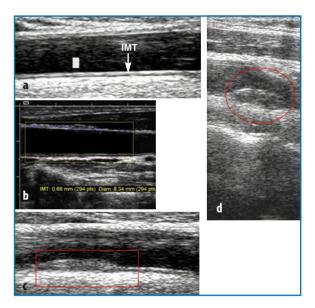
Progressive stages of atherosclerotic plaque build-up in the carotid artery in HIV-infected patients. a An increase of the arterial intima-media thickness (*IMT*) is the first step of this evolution. It occurs before plaque build-up in the arterial wall. b IMT can be measured ultrasonographically using specific analytical software with a limit of detection below 1 mm. c Atherosclerotic plaque progressively accumulates and projects into the arterial lumen. d A more advanced stage of plaque build-up. The speed of plaque accumulation is not predicable. Plaque constitution can be homogeneous or heterogeneous, with a smooth or irregular surface, and be hypoechogenic or calcified. Its evolution depends on a variety of phenomena (e.g. rupture, hemorrhage, and growth)
